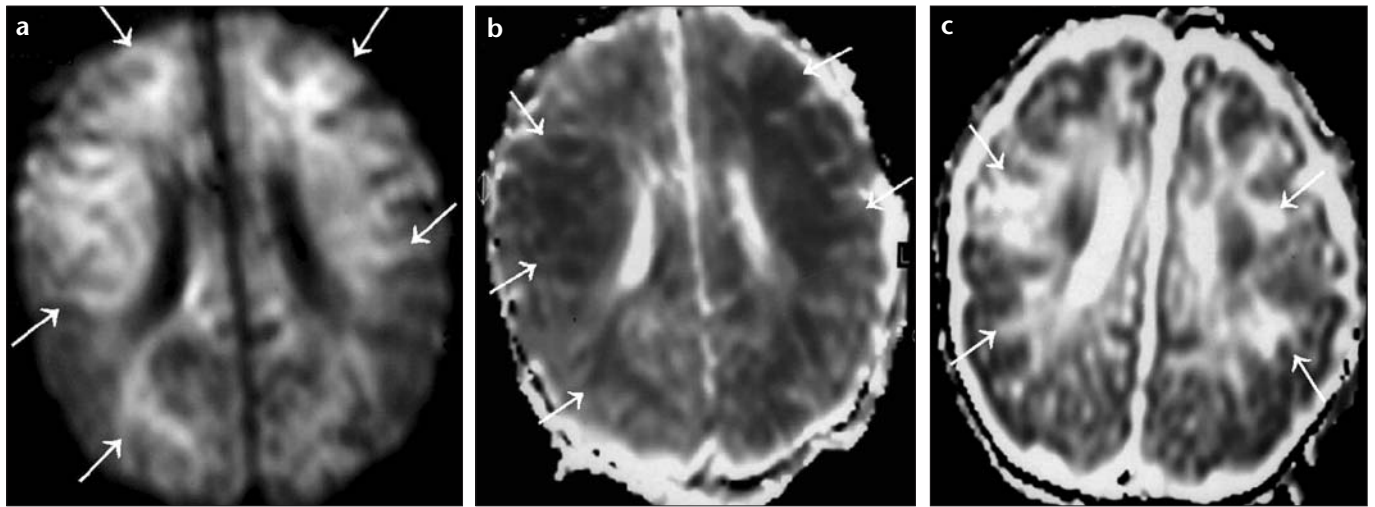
a-c. Stage III hypoxic ischemic encephalopathy. Diffusion-weighted imaging (DWI, b: 1000 s/mm²) obtained within the first 24 hours shows (a) bilateral frontal, parietal, and occipital white matter hyperintense signal (arrows, a); while in ADC map (b), they appear hypointense (arrows, b). In late phase these areas are represented with high signal intensity on ADC map (arrows, c) corresponding to diffusion increase due to chronic ischemic changes.
